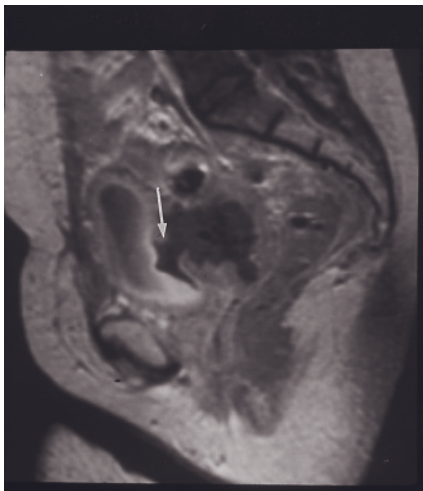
(*Continued*) echo-train spin-echo (*b*) and sagittal T1-weighted gadolinium-enhanced fat-suppressed SGE (*i, j*) images in a third patient with colovesical fistula. A fistulous tract is present in the bladder dome (arrows, *b, i*). Adjacent sigmoid colon is thickened and demonstrates increased enhancement (*j*). Sagittal (*k*) and transverse (*l*) 512-resolution T2-weighted ETSE images in a fourth patient with diverticulitis. There is a signal-void layer superior to the urine in the bladder, consistent with air (large arrow, *k*). A smaller focus of air is located posterior to the bladder wall (small arrow, *k*). A small fluid collection (white arrows, *l*) posterior to the bladder is shown to connect to the bladder by a thin fistulous track (black arrow, *l*).
